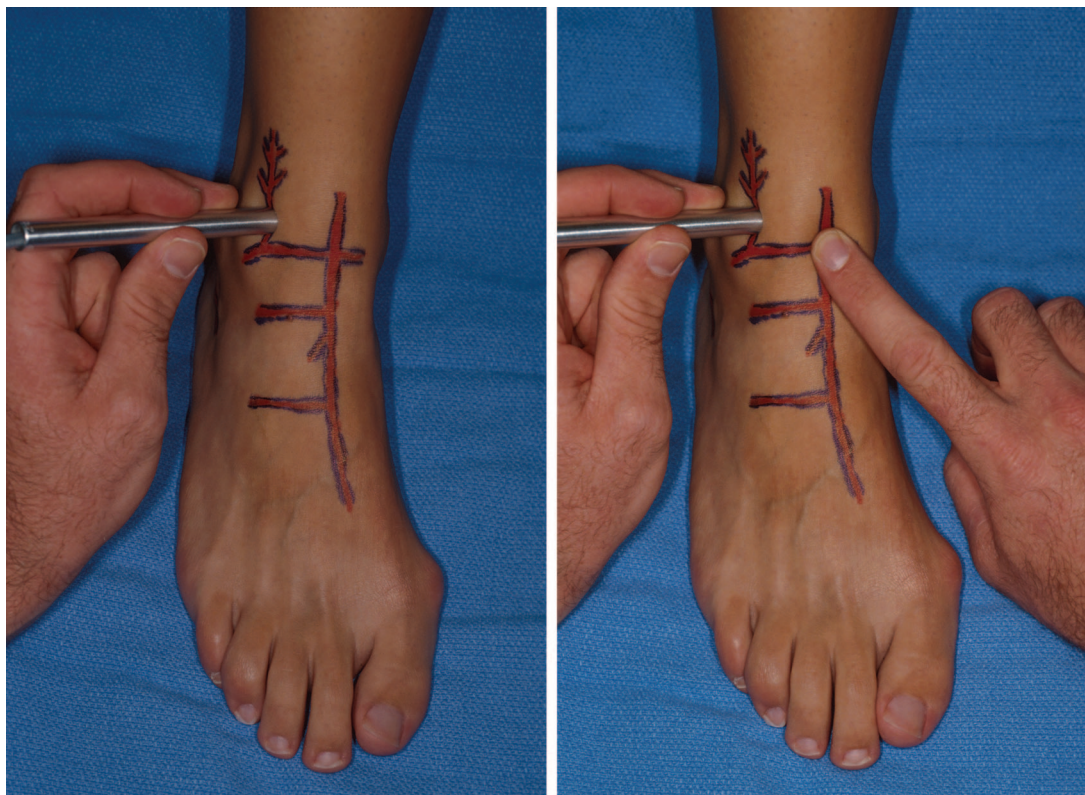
The anterior perforating branch of the peroneal artery is located in the lateral soft area just above the ankle joint between the tibia and the fibula (*left*). Then, the anterior tibial artery is occluded at the takeoff of the lateral malleolar branch (*right*). If the Doppler sounds continue, then there is antegrade flow along the anterior perforating branch of the peroneal artery.
